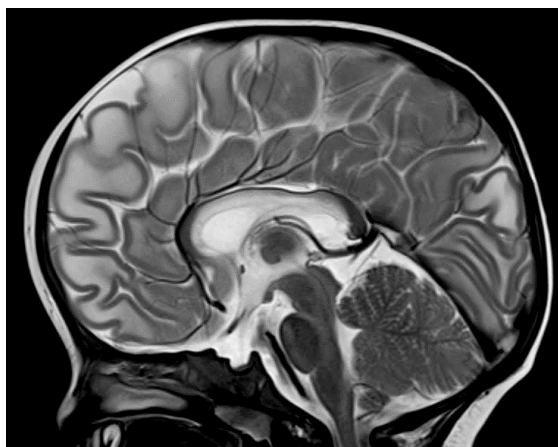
MRI sagittal section in T2-weighted sequence. Corpus callosum hypoplasia without signal abnormality (arrow)
